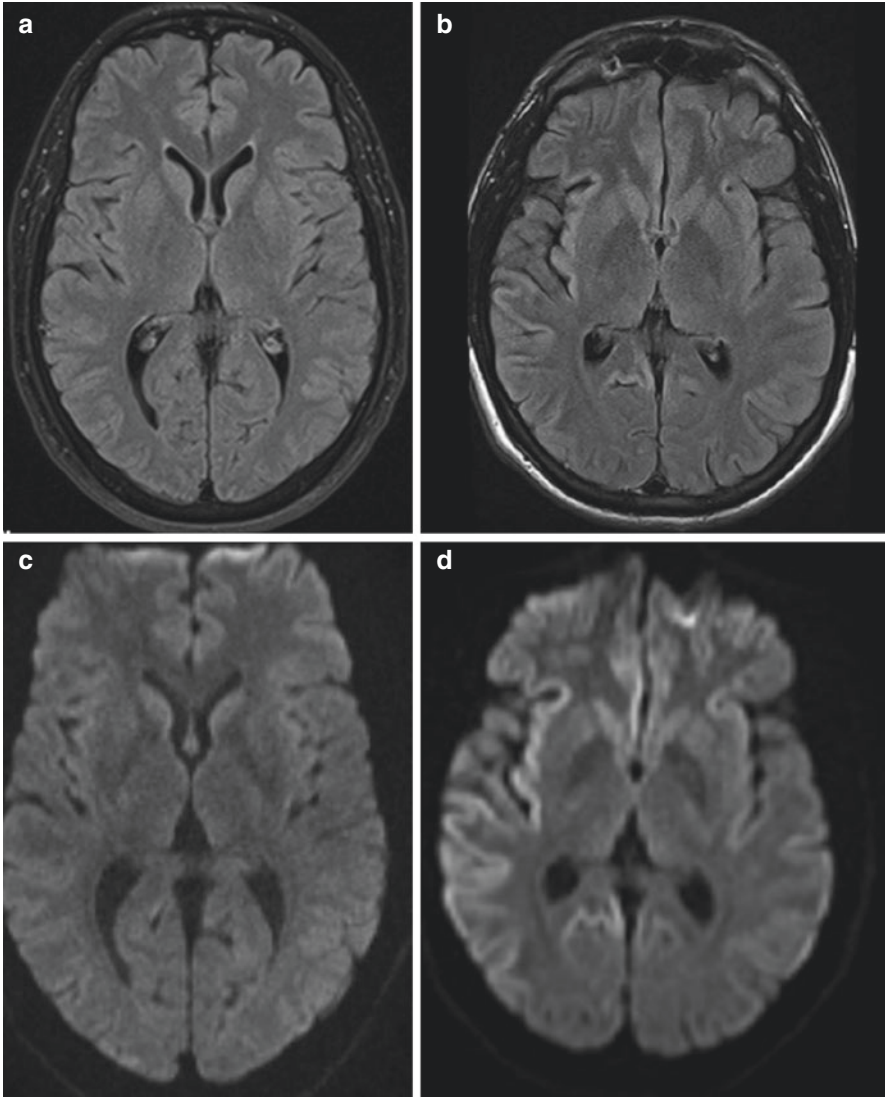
Axial images of brain MRI. (a) MRI-FLAIR sequence of a healthy person. (b) MRI-FLAIR sequence of a patient with prion disease, this image detects cortical ribboning; hyperintensity signal mainly within right insular and temporooccipital cortices in this example. (c) MRI-DWI sequence of a healthy person. (d) MRI-DWI sequence of the same person in image b, this image shows diffusion restriction within the same areas of hyperintensities in FLAIR-sequence
